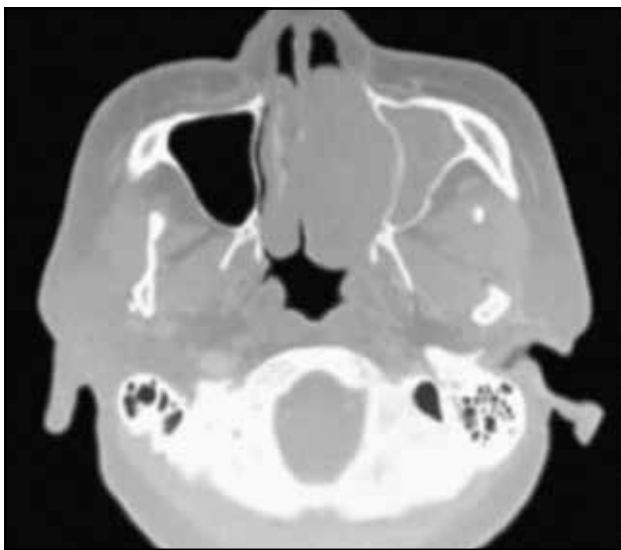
CT paranasal sinus showed complete opacification of the entire left nasal cavity and maxillary sinus, extending to the choana and causing a deviated nasal septum to the right side. The tumor also caused a significant displacement of the left lateral nasal wall into the maxillary sinus. There was hyperostosis of the maxillary sinus wall and nasal septum.
